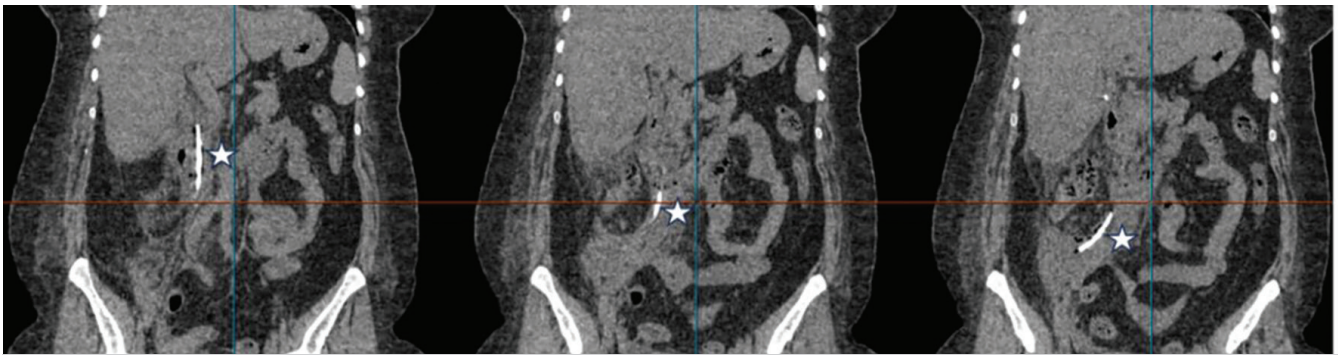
CT scan (the white star marks the biliary stent perforating the duodenum and extending into the retroperitoneal space).
